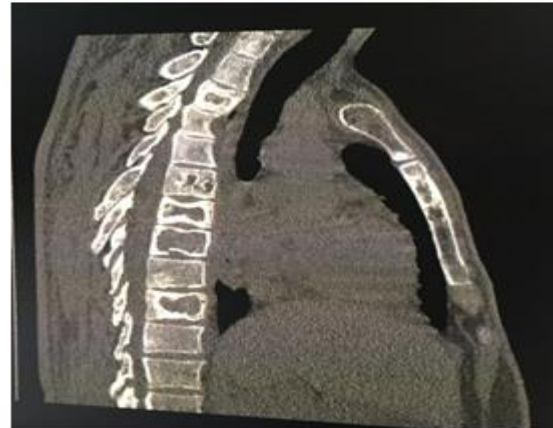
CT sagittal sections of vertebral column. Multiple vertebral
